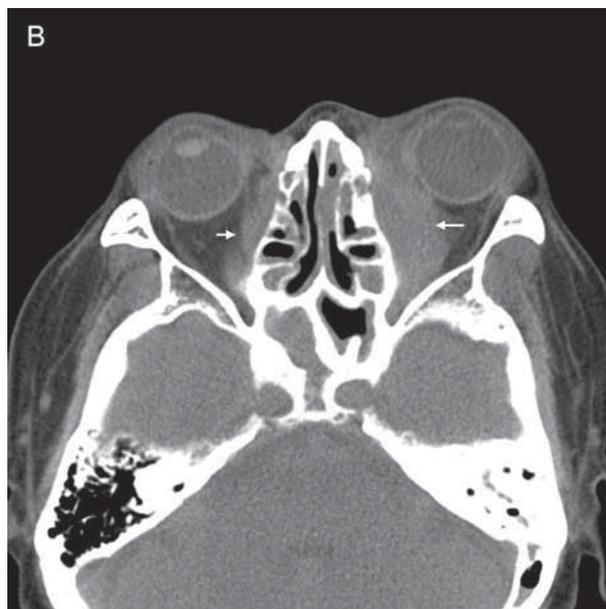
Computed tomography of the paranasal sinuses shows tissue thickening throughout the paranasal sinuses and bilateral medial orbital masses (arrows).
